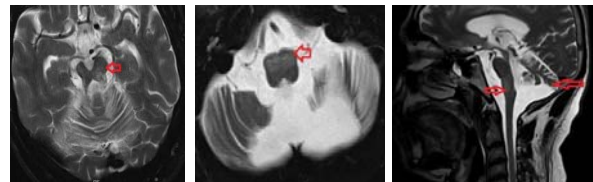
MRI T2 axial and sagittal image shows bilateral inferior olivary nuclei hypertrophy and hyperintensity on T2 weighted images, and mild prominence of superior cerebellar peduncle and diffuse cerebellar atrophy.
